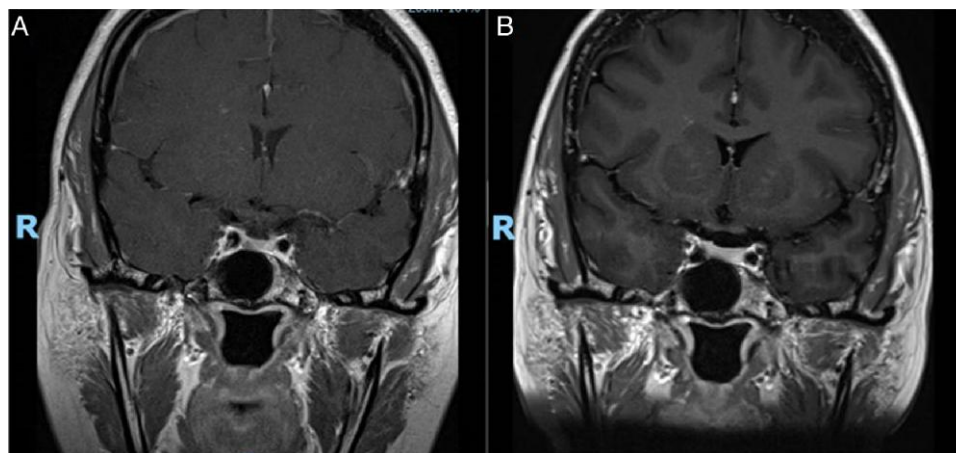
(A) Baseline sagittal, post-contrast T1-weighted MRI demonstrating a 3.5 mm presumed NFPA in the right side of the sella. (B) Sagittal, post-contrast T1-weighted MRI demonstrating shrinkage of the tumour 1 year after the baseline imaging.
